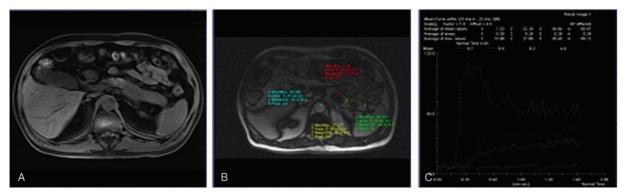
81-year-old male with pancreatic cancer in the body of pancreas. Transverse fat-suppressed T1-weighted images showed widen pancreatic body with slightly low intensity (A). ROIs placement (B). TICs (C). ROIs=regions of interest, TIC=time-intensity curves.
